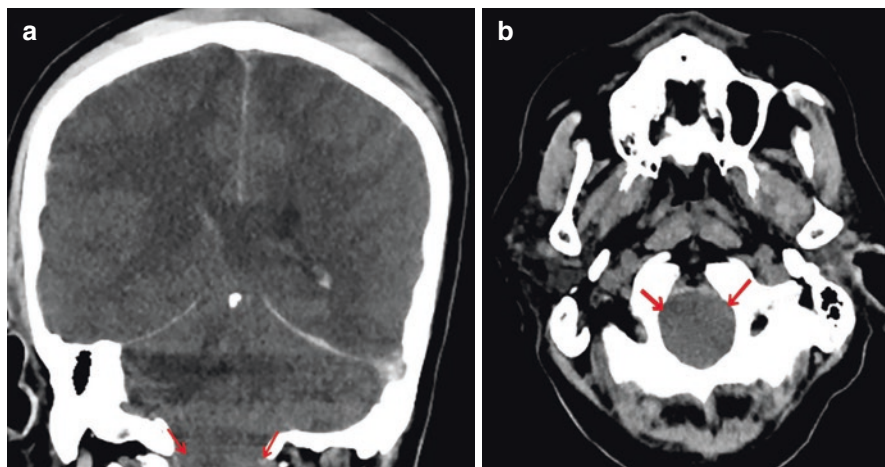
In coronal (a) and axial (b) brain CT images, the plump appearance of the foramen magnum and compression of the medulla oblongata as a result of inferior displacement of the cerebellar tonsils draw attention
